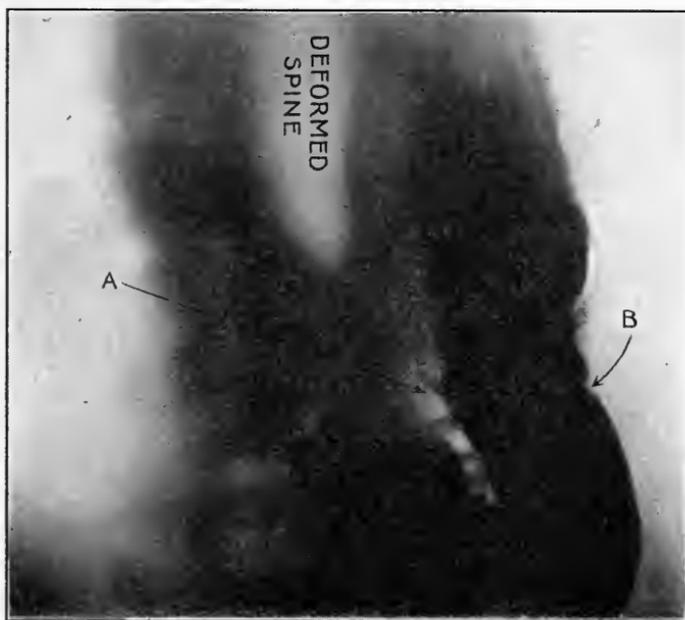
Small lesser curvature ulcer, causing no pronounced deformity but exhibiting one of the inferential signs, roentgenologically, *viz.*, greater curve "incisura." A, site of non-deforming lesser curve ulcer; B, incisura. (Original observation by author.)
